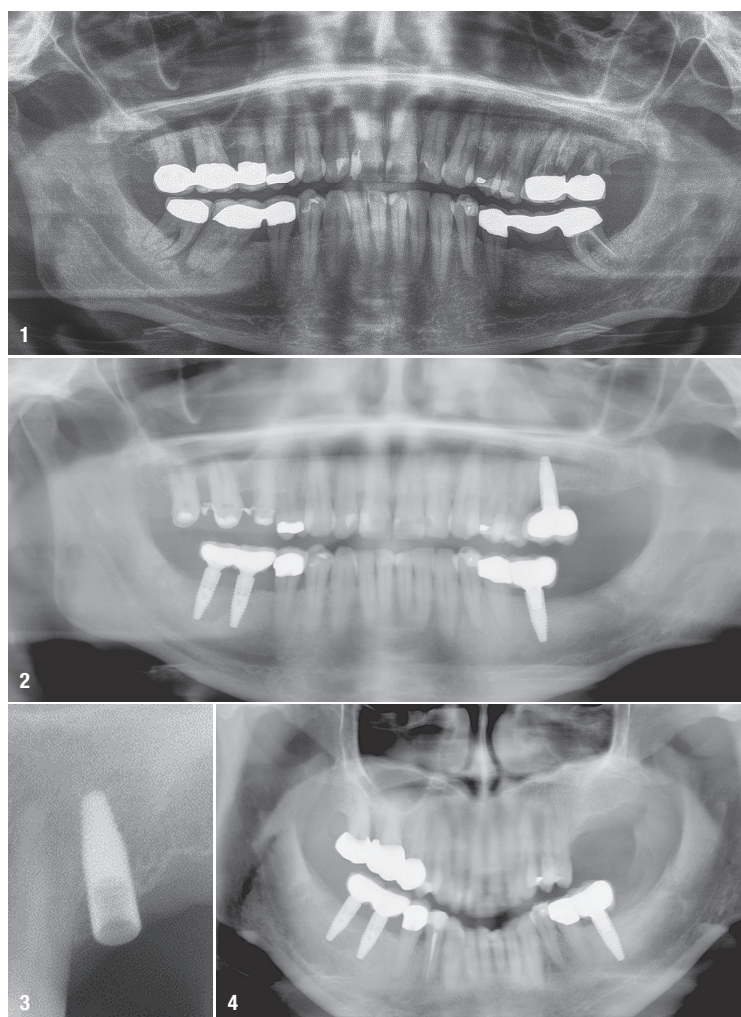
Radiograph showing the situation before the initial implantation. Fig. 2: Radiograph showing the situation immediately after the initial implantation. Fig. 3: Part of a radiograph showing the fractured implant screw prior to removal. Fig. 4: Radiograph showing the situation after implant removal.
